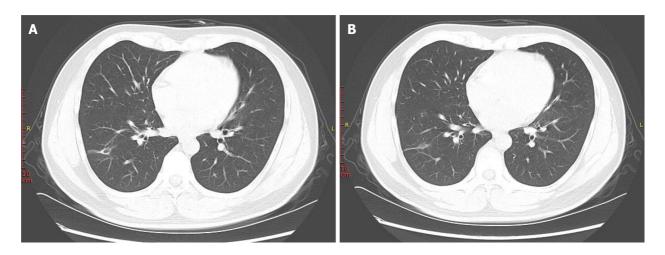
Chest computed tomography scan after 3 mo of antifungal treatment showing near complete disappearance of the nodules and infiltration distributed around the lesions. Only a small number of pulmonary cavities remained at this time. A: The 29th floor scan; B: The 30th floor scan.
